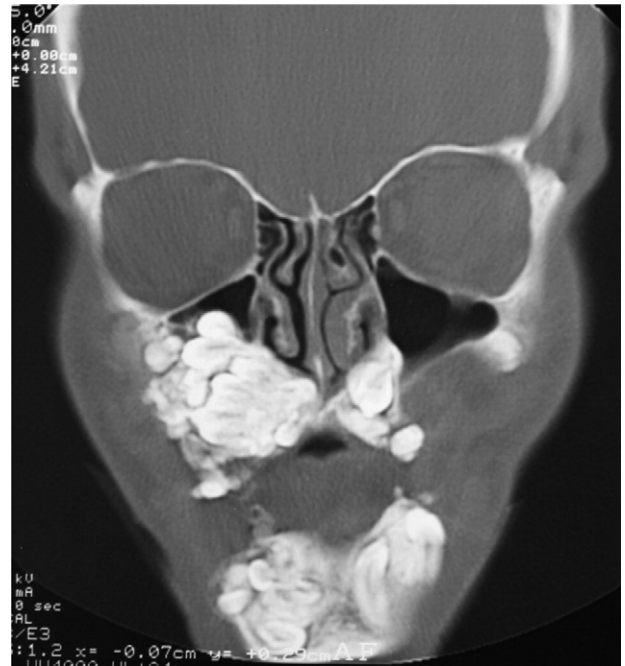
Coronal computed tomography, notice the great involvement of the right maxillary sinus.
